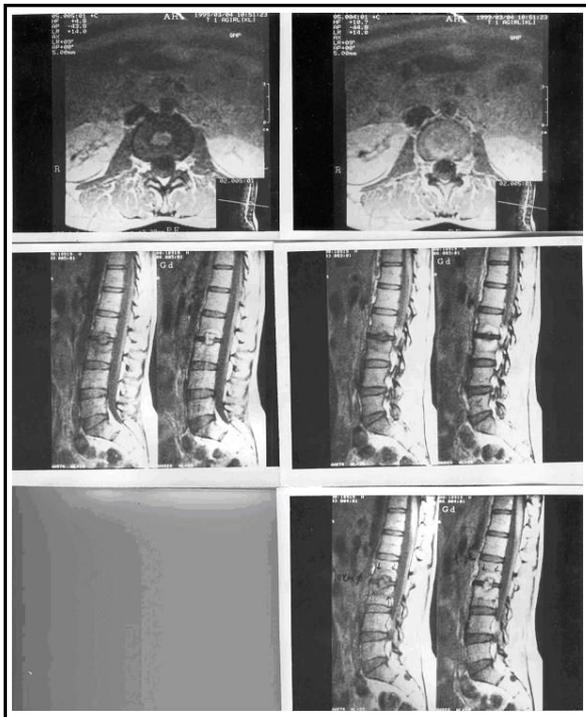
Sagittal and axial magnetic resonance images of the lumbar spine showing L₃-L₄ intervertebral spondylodiscitis in 1999.
